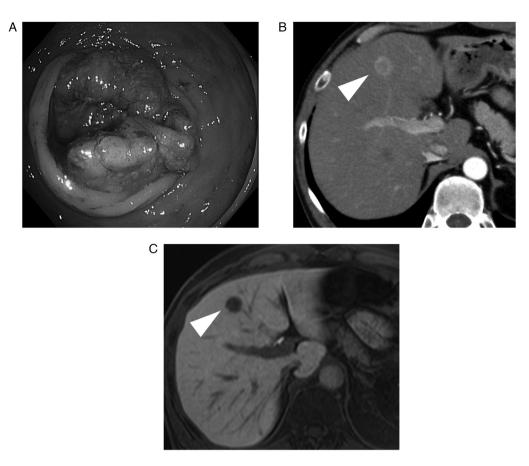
Clinical images of case 1. (A) Preoperative colonoscopy revealed a fungating rectal mass. (B) Computed tomography demonstrated a contrast-enhanced liver mass (10 mm in long diameter in S3), suggesting a metastasis of rectal cancer (white arrowhead). (C) Ethoxybenzyl-magnetic resonance imaging (T1-weighted image) showed that new liver metastases did not appear after 2 months of surveillance.
